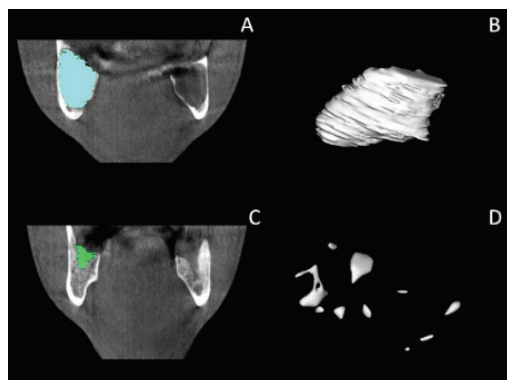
A- Cyst margins were marked in horizontal sections segment by segment pre-operatively and volume value measured with manual segmentation was shown in frontal section of CBCT image. B- The volume of mandibular cyst that was measured by manual segmentation was demonstrated in three dimension C- Same process was repeated at the end of 1 year follow-up period on frontal CBCT section. D- Three dimension reconstruction showed diminished volume of the mandibular cystic lesion.
